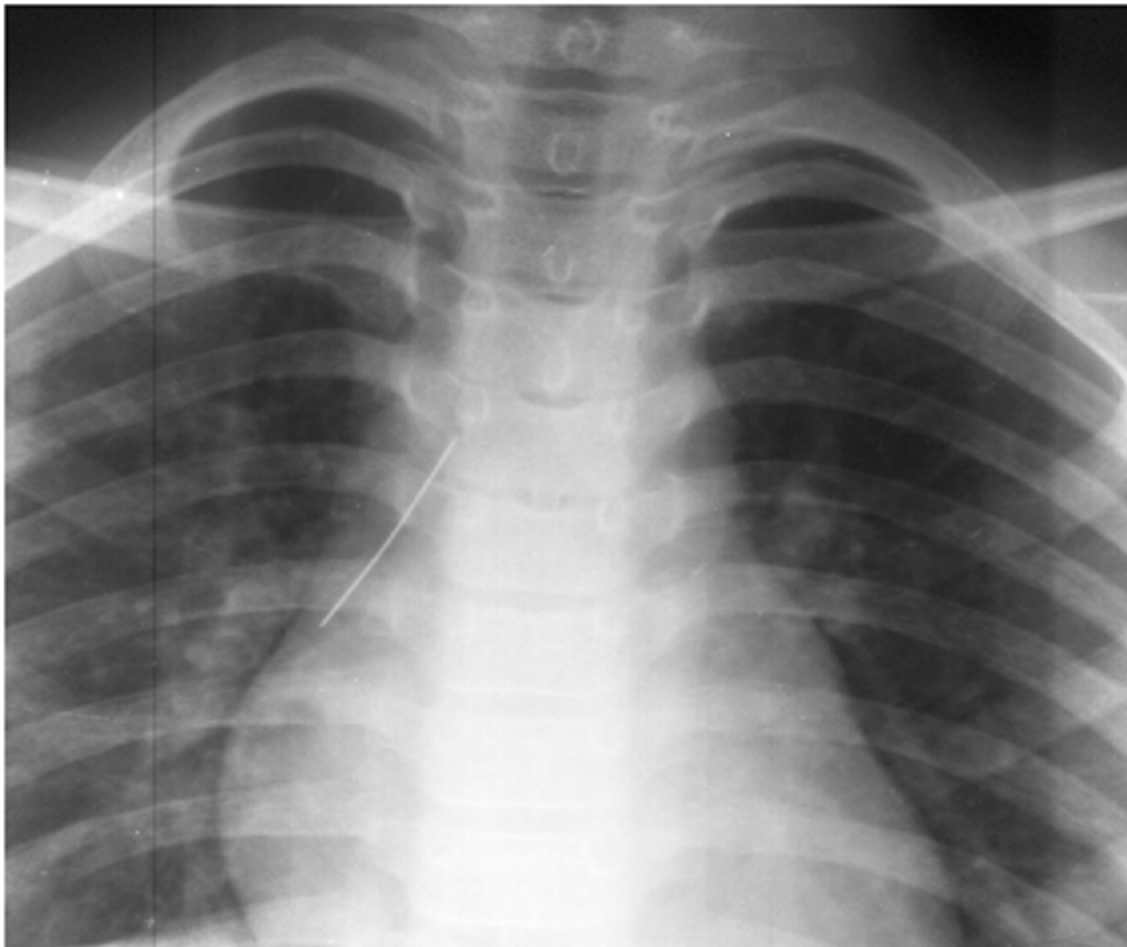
Initial Chest Radiograph Taken Showing A Radio-opaque Linear FB in the Right Bronchus. No Visualized Pneumothorax, Pneumomediastinum or Haemothorax Seen
